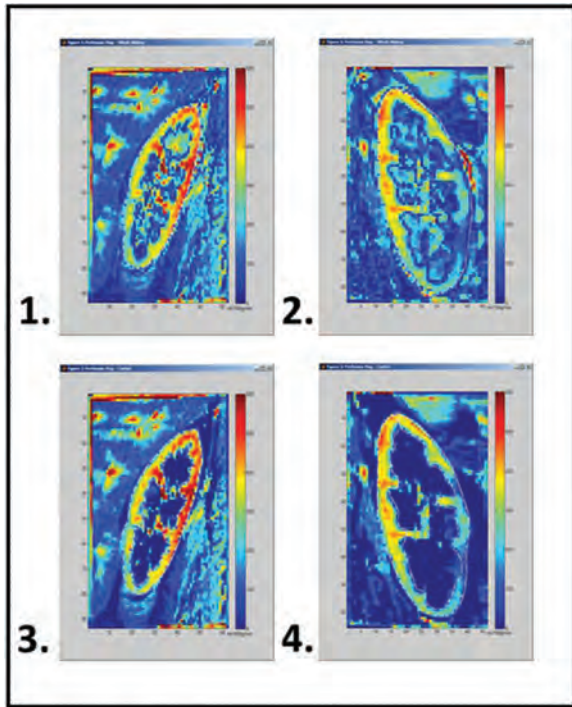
ASL MRI perfusion maps from a potential live donor demonstrating whole kidney (1 & 2) and cortical (3 & 4) perfusion
